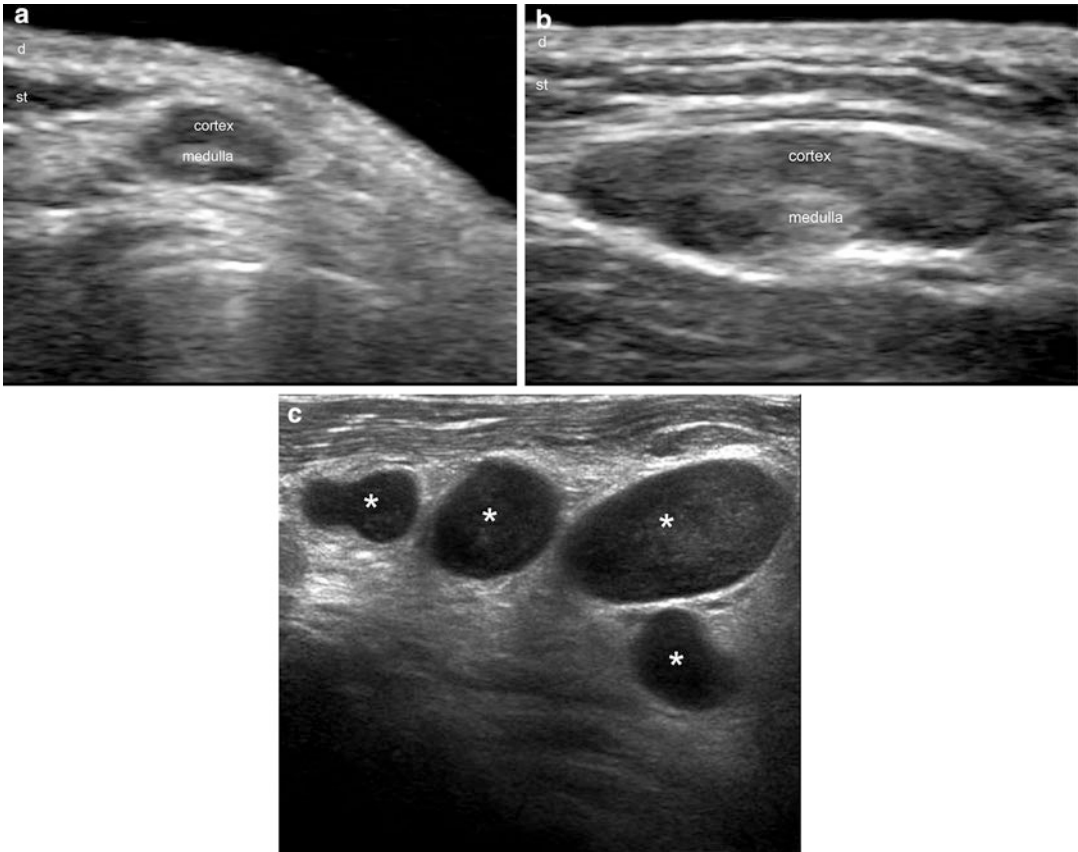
Lymph nodes (grayscale ultrasounds; (a) and (b): transverse views; (c): longitudinal view). (a) Normal lymph node: well-defined, oval-shaped structure with hypoechoic cortex and hyperechoic medulla. (b) Inflammatory lymph node: enlarged oval-shaped structure that
